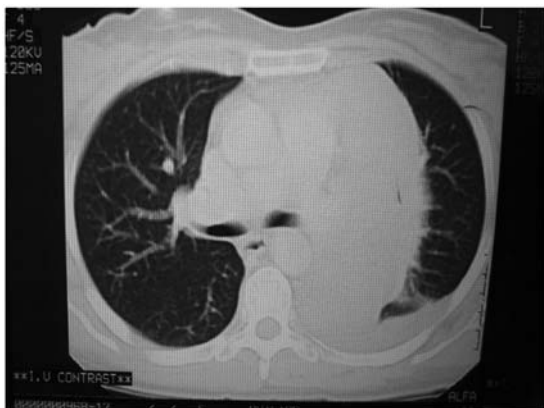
Computed tomography scan showing a left-sided solitary fibrous tumor.
